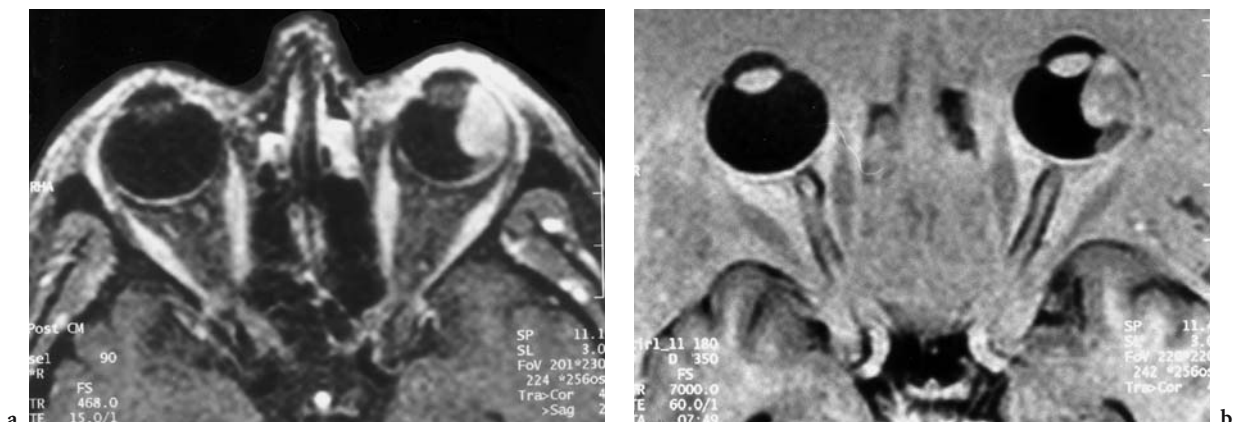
A 59-year-old woman with progressive visual deficit of the left eye. Diagnosis: choroidal melanoma with secondary infiltration of the ciliary body. Axial MRI: a T1-weighted, contrast-enhanced view outlining the tumor, which apparently originates in the lateral ciliary body; additional retinal detachment in the posterior part. b Corresponding IR image providing a more conclusive delineation of the pathologic process
